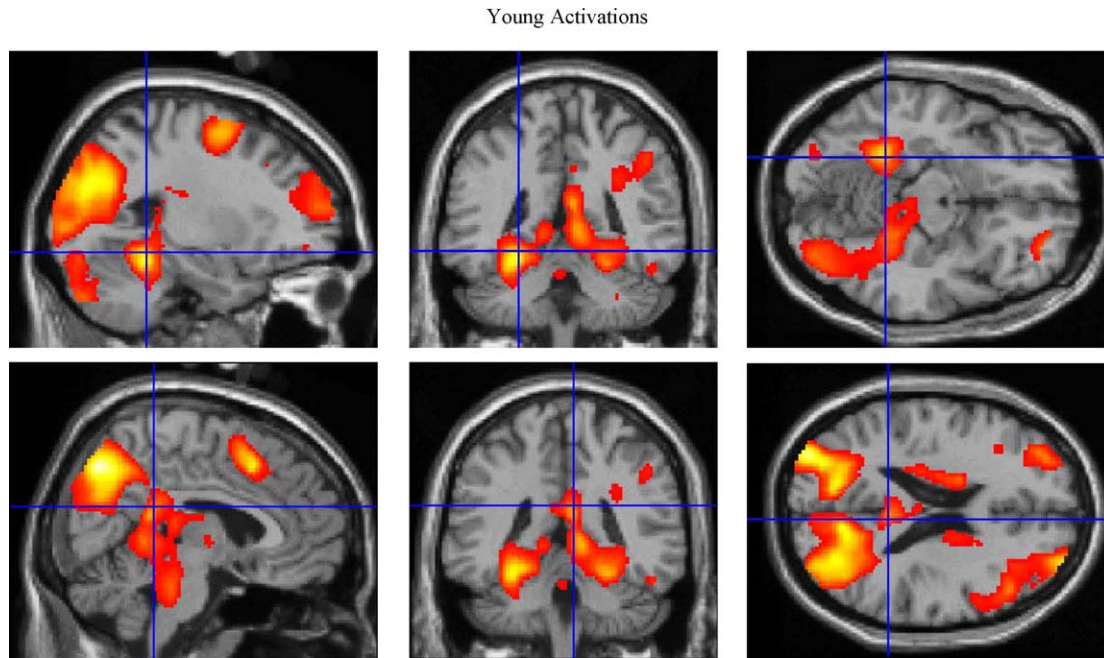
Activations in young subjects during navigation compared to control condition. Activation images are superimposed on a single subject T1-weighted MRI in the sagittal, coronal and axial planes displayed in standardized space. These images show activation in the posterior parahippocampal gyrus, retrosplenial cortex, cerebellum, pre-frontal cortex, precuneus and widespread regions of the parietal lobe.
